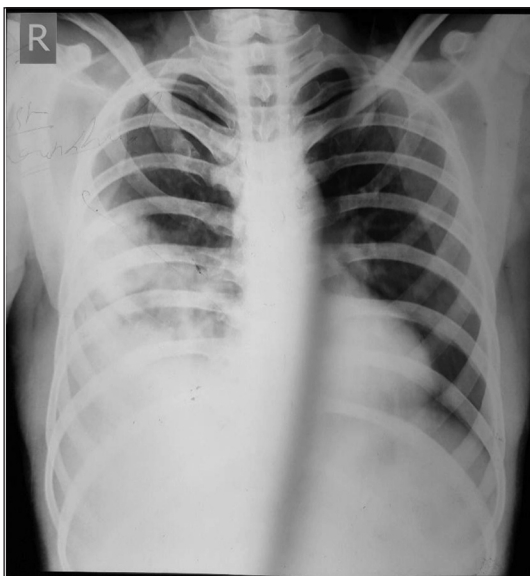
Chest X-ray showing right side consolidation and pleural effusion
